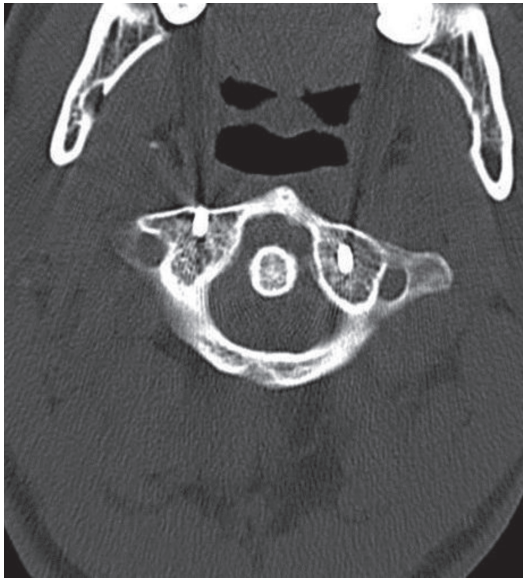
CT Scan Cervical Spine Revealing Transarticular Screws Insertion in C1-C2 Joint
